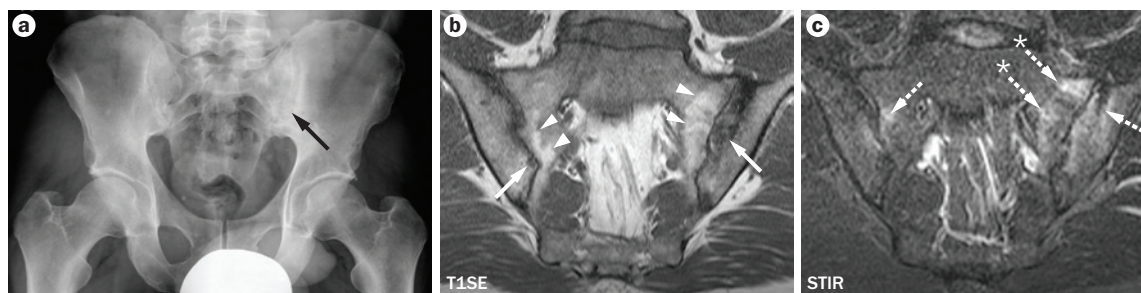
Sacroiliitis in a patient with axSpA as observed on a pelvic radiograph and on SIJ MRI images. a | Pelvic radiograph of a 40 year old, *HLA-B27* positive male who meets the radiographic criteria of the modified New York criteria for AS. Both SIJ show blurred joint margins, sclerosis and erosion, more pronounced on the left side with pseudo-widening of the joint space (black arrow). b | Demonstration of two features that can be detected on T1SE sequence MRI images of the SIJ: joint erosion (arrows) and fat infiltration (arrowheads). Extended erosion in the left iliac bone corresponds to radiographic pseudo-widening of the left SIJ. c | STIR MRI sequences reveal bone marrow edema (broken arrows, with and without asterisks). The dotted arrows with asterisks point to ongoing active inflammation within the areas of fat infiltration detected by T1SE MRI. Abbreviations: AS, ankylosing spondylitis; SIJ, sacroiliac joint; axSpA, axial spondyloarthritis; STIR, short tau inversion recovery; T1SE, T1-weighted spin-echo.
